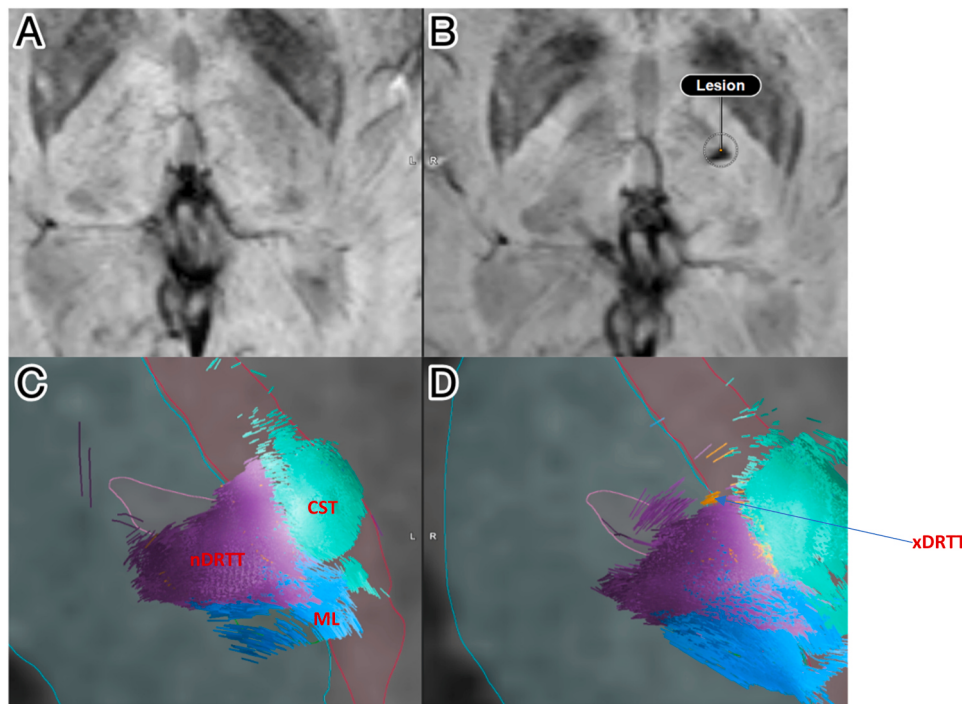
Lesion sites and image processing in a 72-year-old right-handed male with ET. (A) Pre-op SWI. (B) Immediate post-op SWI of the ablation site. A triangular-shaped lesion is observed. (C) FT2 tractography overlay with superimposed stereotactic atlas on pre-op axial T1-weighted image. The nDRTT (purple), medial lemniscus (blue), and corticospinal tract (green) are shown. The xDRTT could not be successfully tracked. (D) FT2 tractography overlay with superimposed stereotactic atlas on immediately post-op axial T1-weighted image. The nDRTT (purple), xDRTT (orange), medial lemniscus (blue), and corticospinal tract (green) are shown. Atlas registration shows the internal capsule (red outline), thalamus (blue outline), and VIM (pink outline). Abbreviations for key structures are displayed on the images in bold red text for clarity.
